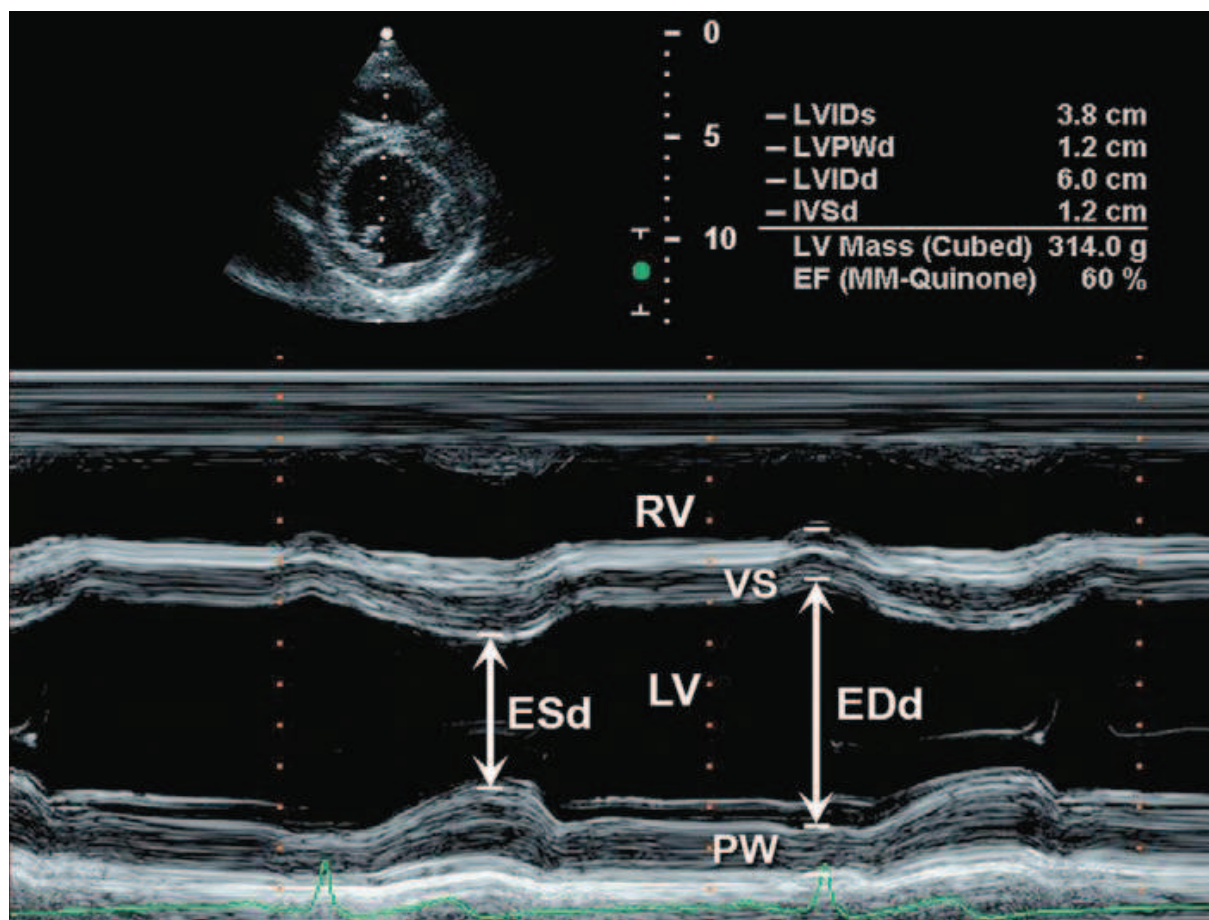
Two dimensional guided M mode echocardiogram of left ventricle at papillary muscle level ⁽⁷³⁾
